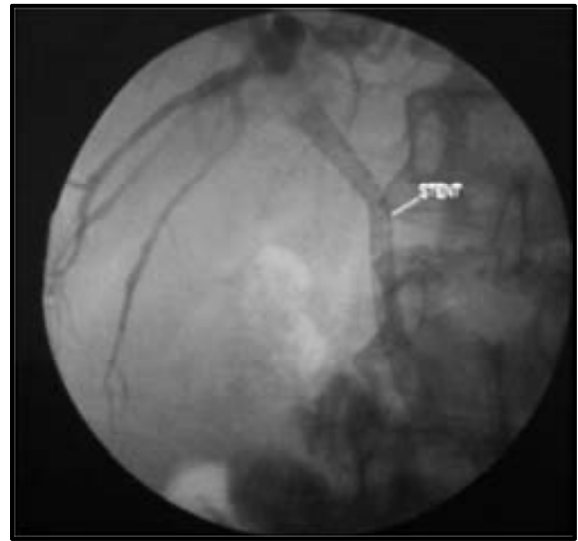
Case (2) PTC image of patient with Distal cholangiocarcinoma diagnosed by CT and managed by metallic stent insertion.
